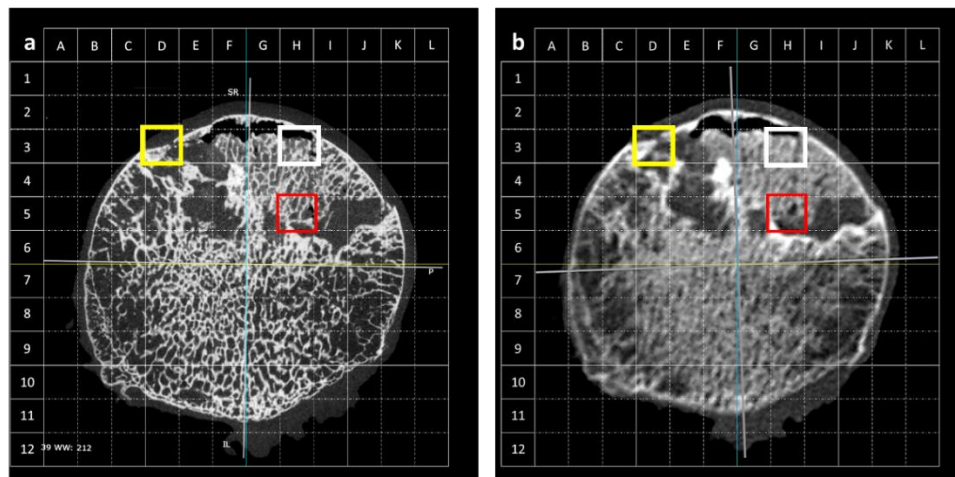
Corresponding (a) μ CT and (b) MDCT sagittal reformats of an osteonecrotic femoral head. A cortical bone microfracture is visible in both D3 grid boxes highlighted in yellow. The trabecular microfracture seen at μ CT (H5, highlighted in red) is not visible at MDCT (H5) whereas the trabecular microfracture in H3 (highlighted in white) is visible on both techniques.
